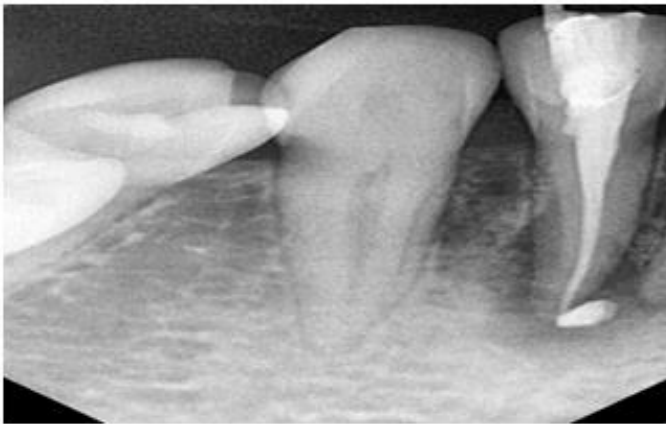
obturation radiograph
